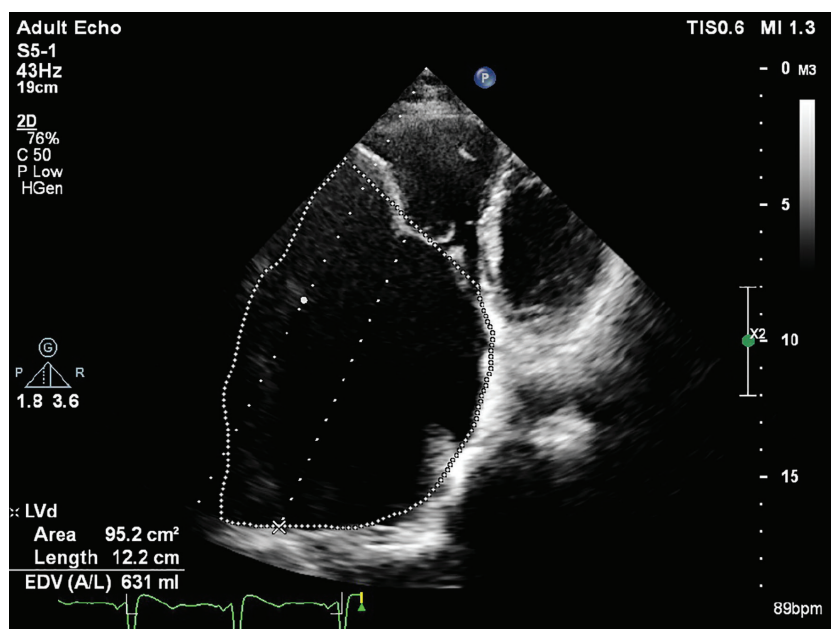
The Right Atrial Volume Estimated by Transthoracic Echocardiogram in Apical View
